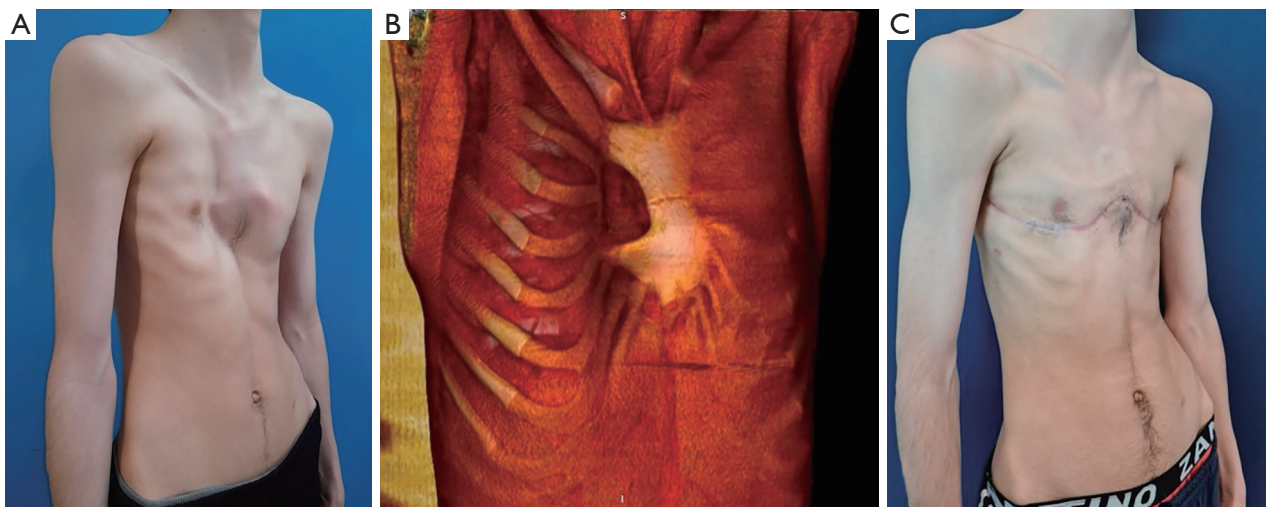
Complex patient with Poland Syndrome, pectus excavatum, sternal deformity, and chondral agenesis. (A) Preoperative, medical photograph showing extensive asymmetric deformity. (B) 3D-CT reconstruction showing the rotated sternum with a right defect and right chondral agenesis causing a lung herniation. (C) Postoperative photograph showing symmetric hemithoraxes and correction of prior pectus excavatum. 3D, three-dimensional; CT, computed tomography.
